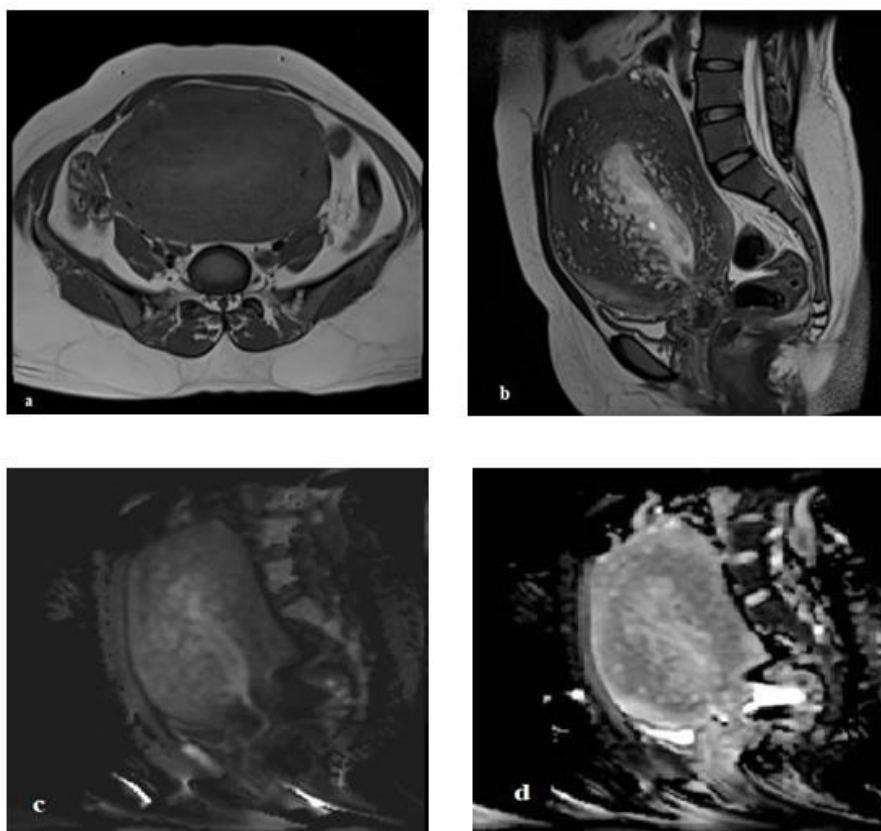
(a)T1W axial sequence shows enlarged uterus with asymmetric thickening of junctional zone which shows homogenously isointense signal.(b) T2W sagittal sequence shows that there is ill-defined hypointense myometrial lesion with multiple tiny hyperintense foci embedded within myometrium. (c)DWI sagittal sequence shows areas of low signal in the solid areas of mass lesion. (d) ADC sagittal sequence shows there are corresponding high ADC values ($1.231 \times 10^{-3} \text{mm}^2/\text{sec.}$)
